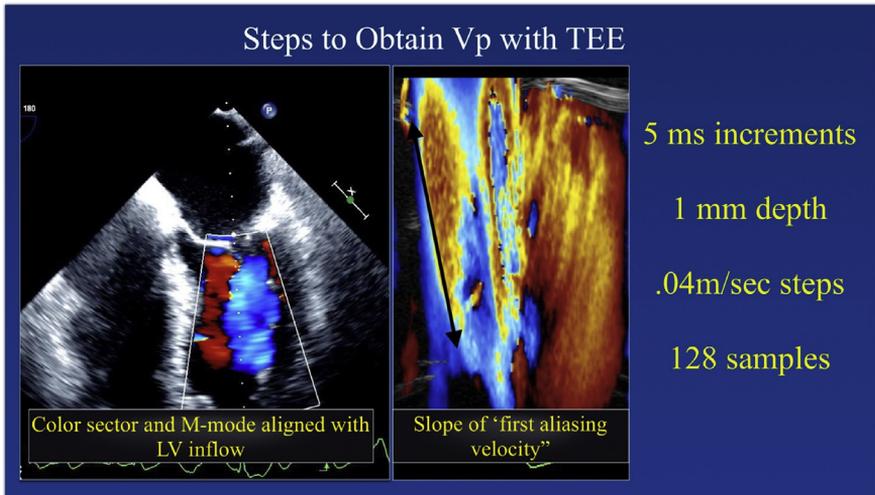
Transmitral flow propagation velocity (V_p). Left panel, Mid-esophageal 4-chamber view showing the color flow Doppler sector and M-mode cursor aligned with the left ventricular (LV) inflow. Right panel, measuring the slope of the first aliasing velocity to obtain the transmitral flow propagation velocity.
